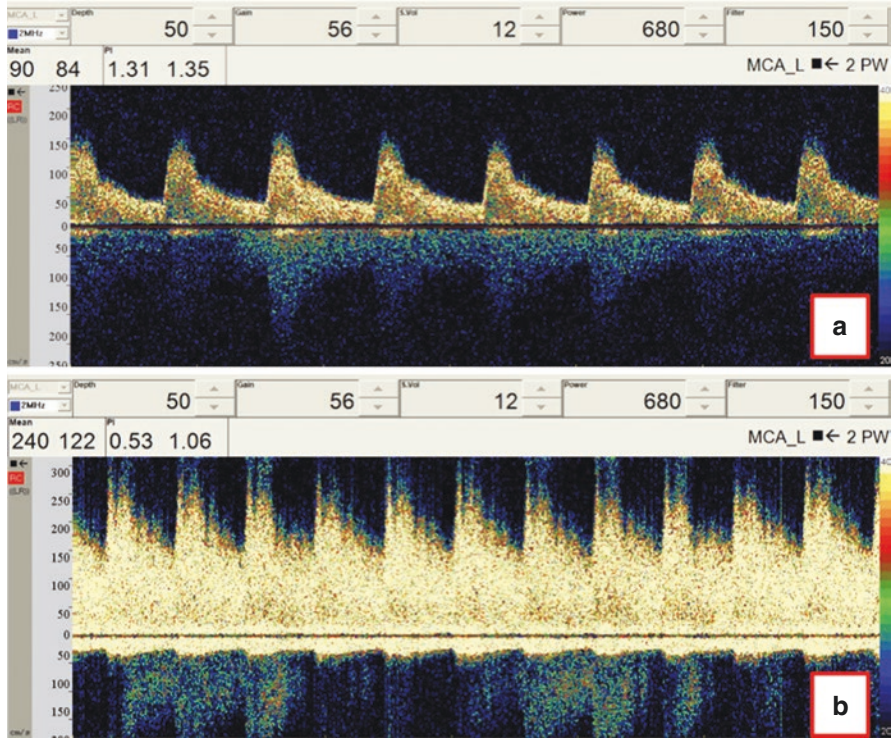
Vasospasm. Panel A. Transcranial Doppler waveform from the left middle cerebral artery in a patient on day 3 after aneurysmal subarachnoid hemorrhage shows a mean velocity of 90 cm/s. Panel B. Transcranial Doppler waveform from the left middle cerebral artery in the same patient from Panel A on day 11 shows a mean velocity of 240 cm/s (diastolic notch is still present)
